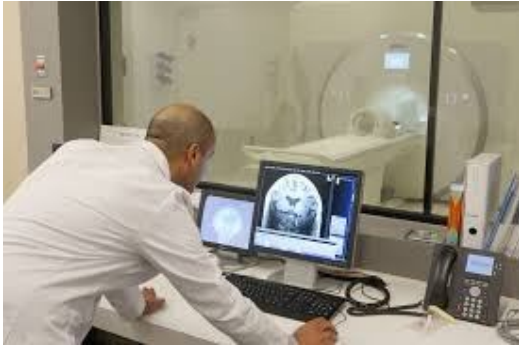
MRI room control
